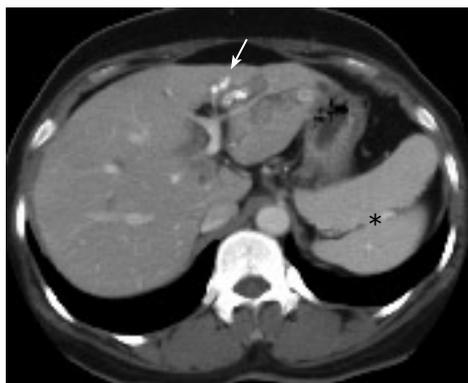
Abdominal computed tomography scan. Polysplenia (asterisks) are present in the left upper quadrant and it shows the left lateral intrahepatic duct stones with atrophy (arrow).
